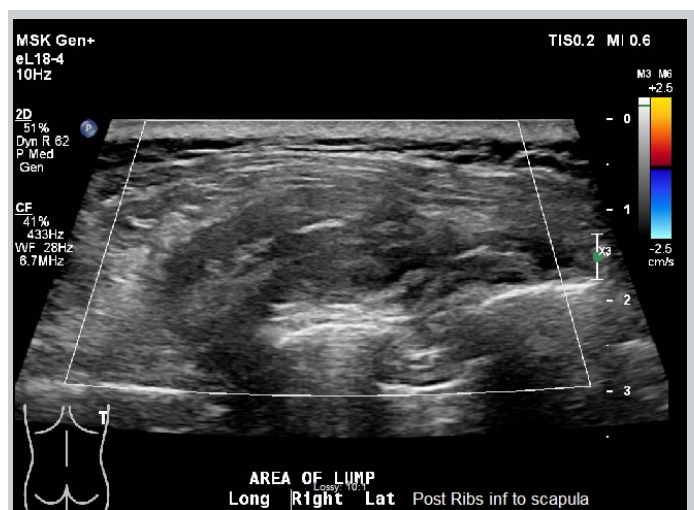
Formal Ultrasound. Posterior right chest along the inferior aspect of the scapula superficial to the scapula and along the chest wall, a 4.8 x 4.1 x 1.9 cm heterogeneous soft tissue mass without significant flow seen on color Doppler imaging. It is located deep to the superficial musculature. Initial impression of a complex nonspecific soft tissue mass reflecting swelling from surgery or an injury. Neoplasm was not excluded.
